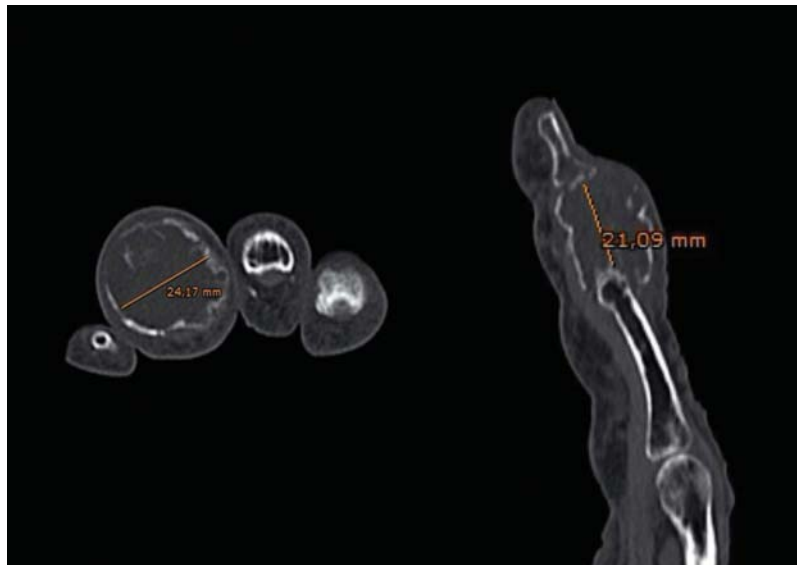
Helical computed tomography images revealing an expansive lesion at the middle phalanx of the fourth finger of the hand (explanation in text).
